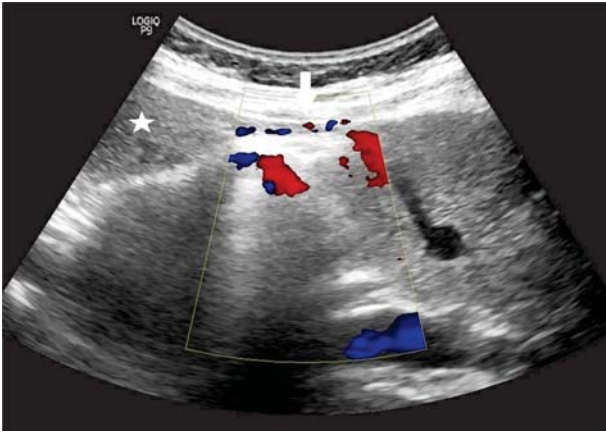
Abdominal color-doppler ultrasonography – sagittal scan: soft tissue area (star) in subhepatic space with vascular connection (star) to the right liver lobe
